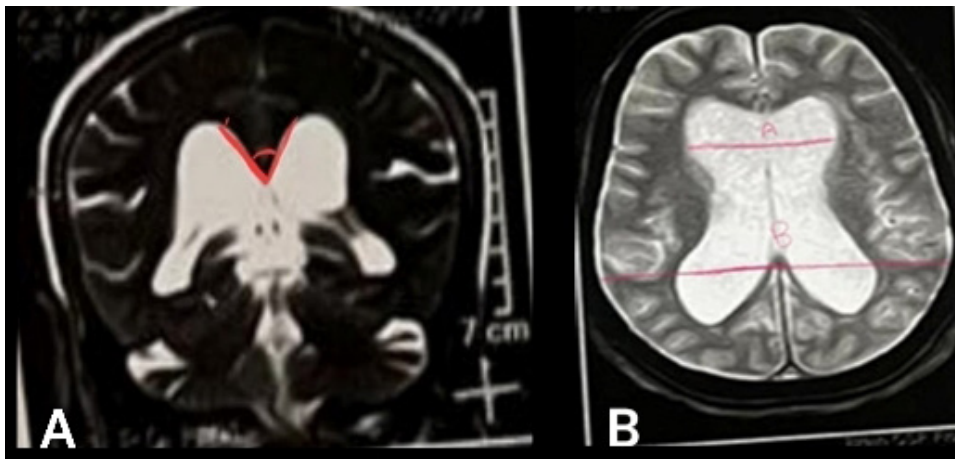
(A): MRI T2 weighted coronal cut of female 79 years old revealing acute callosal angle (Angle measured on coronal image at the level of posterior commissure perpendicular to the anterior commissure posterior commissure plane) and tightness of subarachnoid space at high convexities. (B): Axial MRI A represents the Evan's index (The ratio widest width of frontal horns and B represents the widest biparietal diameter).
